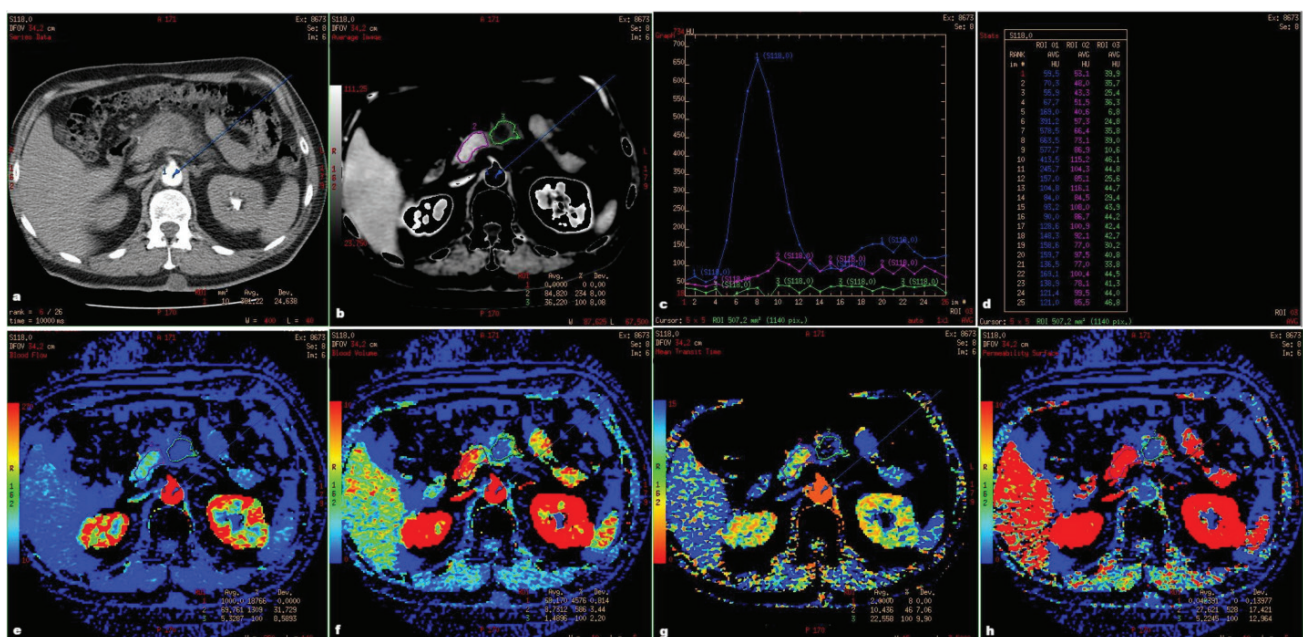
Analysis of the CT perfusion study: a) A CT image of the suspected tumor in the body of the pancreas and dot ROI in the abdominal aorta (blue) b) The reference image of the corresponding cross section of the CT perfusion study with the freehand ROIs in the tumor (green) and surrounding healthy pancreatic tissue (violet) c) The arterial, tumor and healthy pancreatic tissue time-density curve d) The table view of the arterial, tumor and healthy pancreatic tissue time-density curve e) BF f) BV g) MTT e) PS (Images are author's work and written informed consent for publishing their anonymous images was obtained from a patient)
